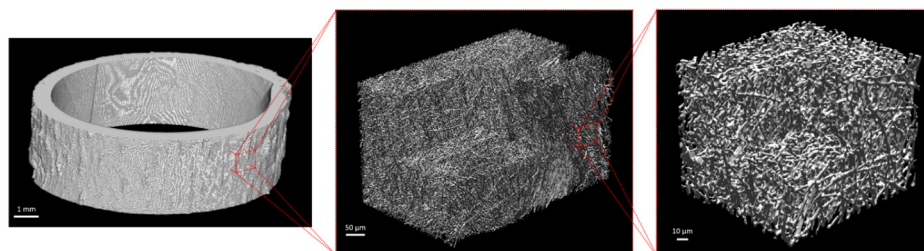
Three μ CT 3D renderings at three magnifications: left: the whole matrix, middle: a large volume of interest ($500 \times 300 \times 300 \mu\text{m}^3$), and right: a small volume of interest ($100 \times 100 \times 100 \mu\text{m}^3$).
